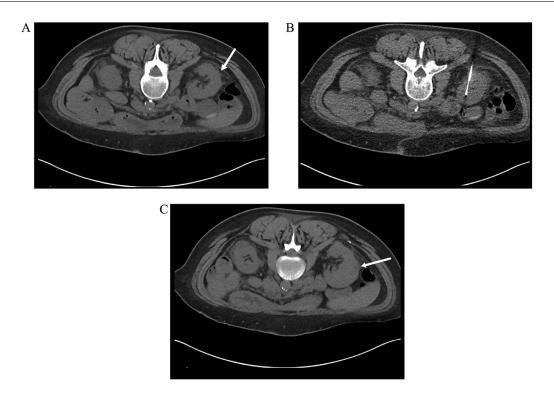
Preprocedural limited CT (A) demonstrating biopsy target with substantial peri-renal fibrosis (white arrow). Intra-procedural CT (B) demonstrating position of the biopsy needle. Post-biopsy CT (C) demonstrating new right subcapsular hematoma (white arrow).
